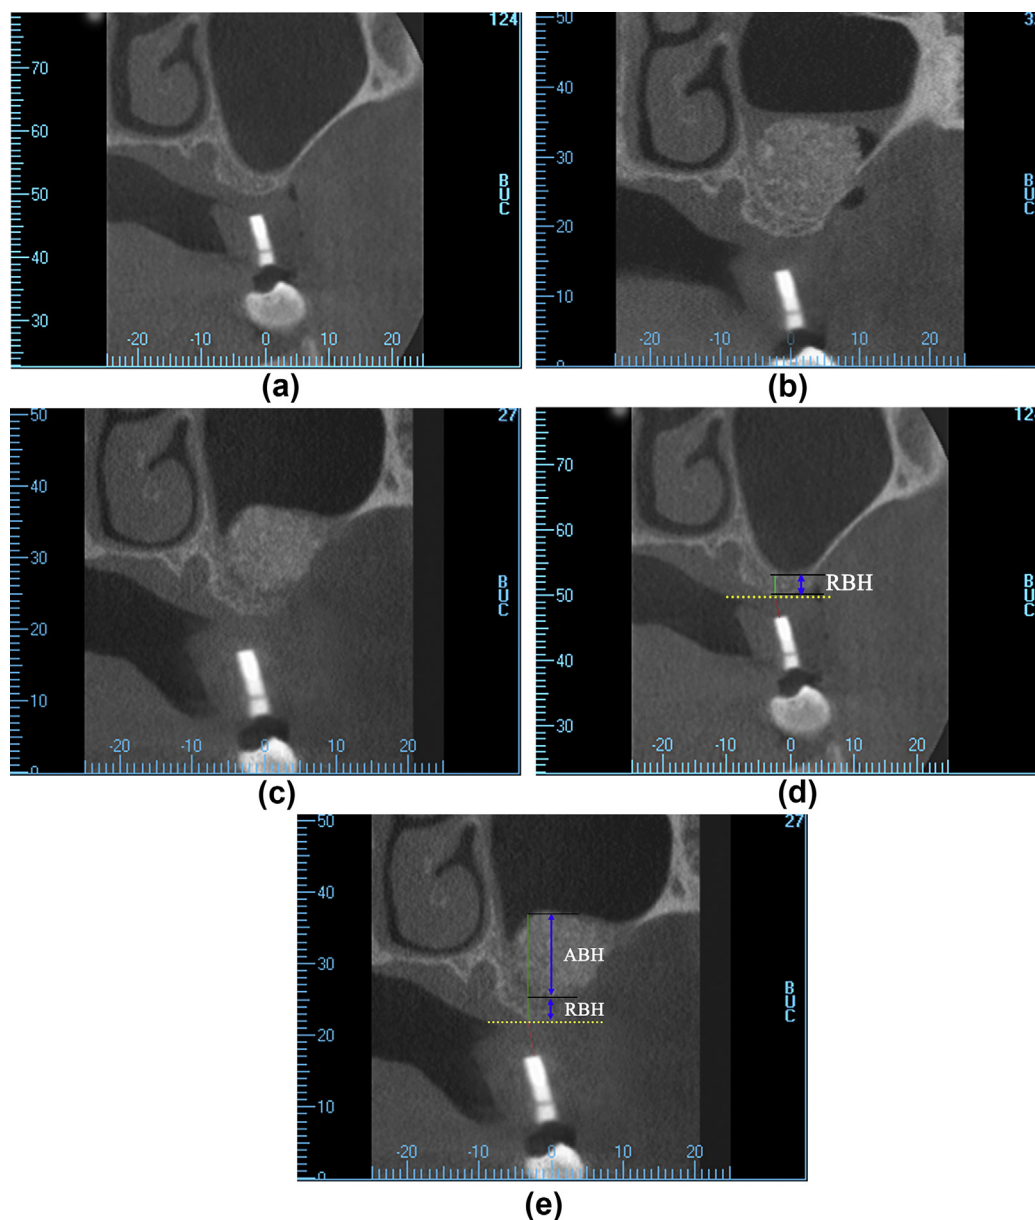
Cone-beam CT images obtained after the standardization of each location using a surgical guide (a) before sinus floor elevation via the lateral approach (LSFE) (T0), (b) after surgery (T1), (c) 6 months after surgery (T2), (d,e) standardized calculation of RBH(residual bone height) and ABH(alveolar bone height).
